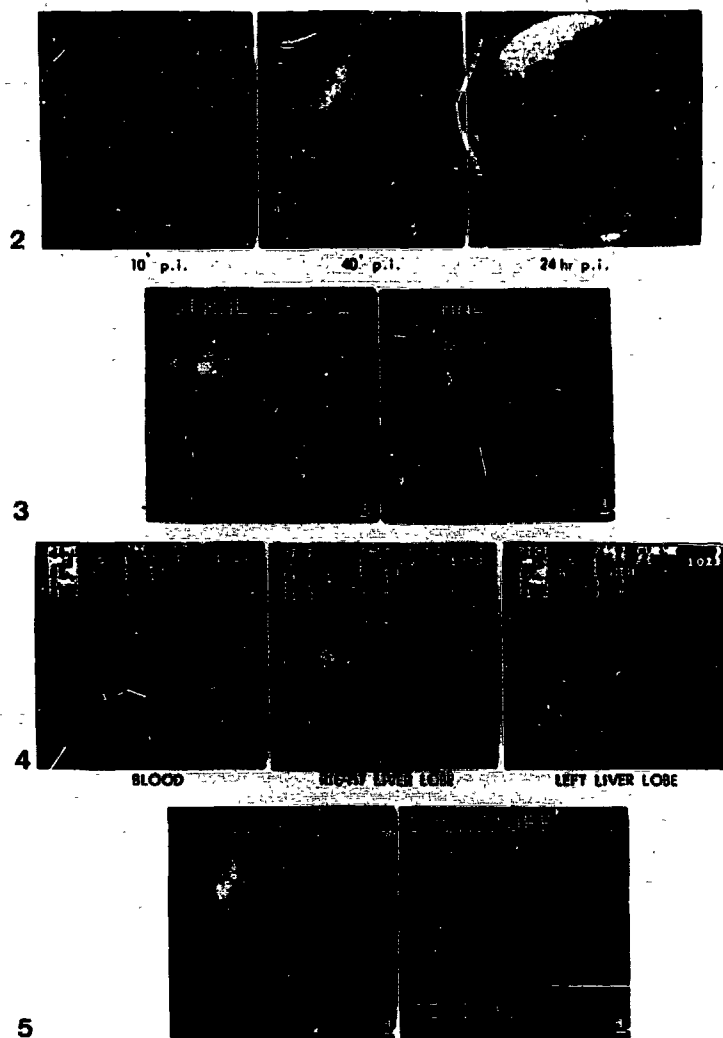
2-5 Cholescintigraphy in a patient with bile duct obstruction due to pancreas head tumour.
